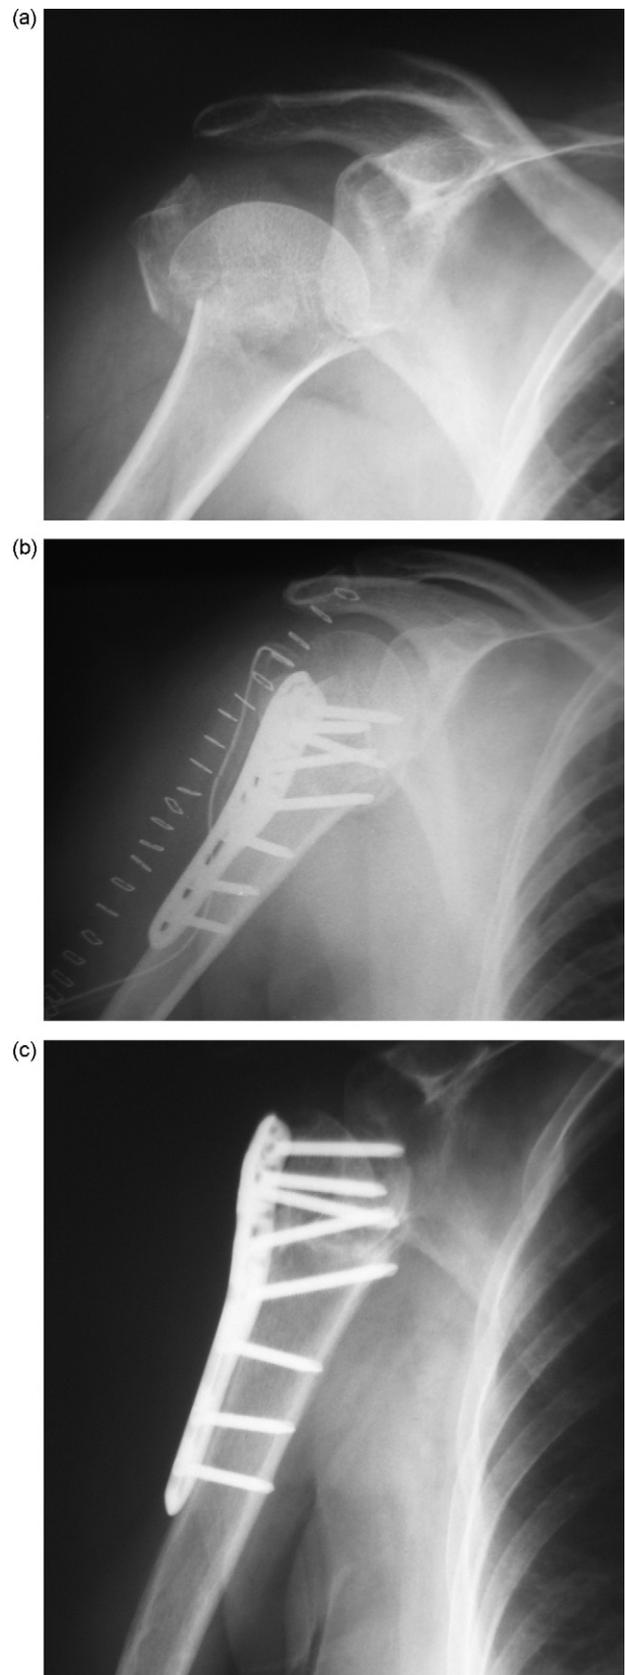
(a) Preoperative X-ray of a three-part proximal humeral fracture. Note the head fracture line located in the humeral anatomical neck. (b) Immediate postoperative X-ray shows satisfactory fracture reduction. (c) Fourteen months postoperatively humeral head avascular necrosis is evident, leading to subsequent head collapse.
